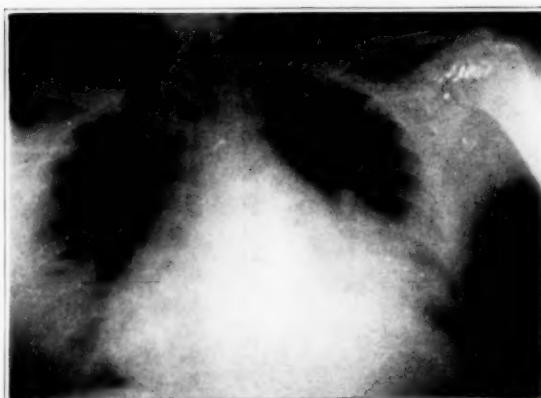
A*. Adhesive pericarditis with pericardial and pleural effusion. Marked enlargement of cardiac shadow toward both sides. The roentgenograms *A-C* are those of Case No. 2.
